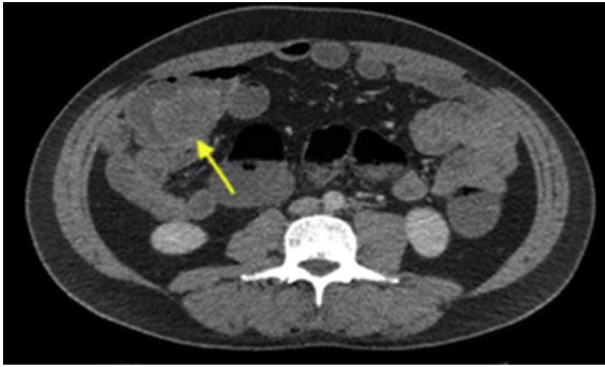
Axial contrast-enhanced computed tomography (CT) scan demonstrated thick-walled cystic lesion in the right side of the right lower quadrant.
